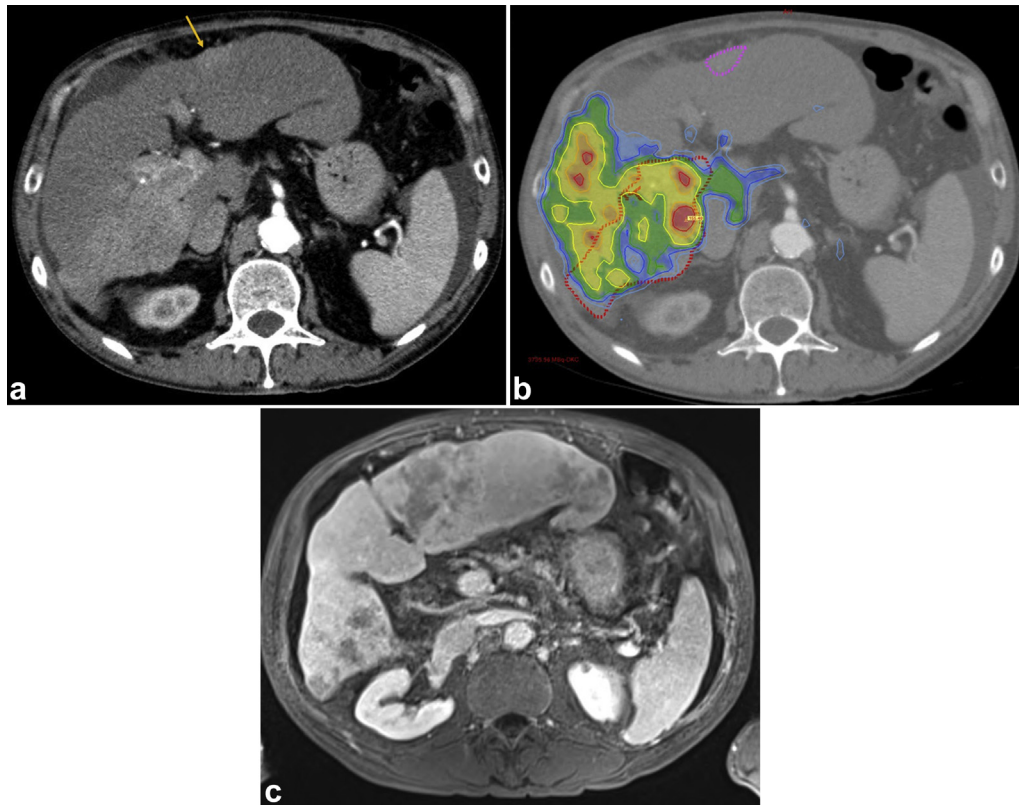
Example of incomplete targeting (limited contralateral disease). (a) Baseline CT scan with infiltrative HCC in the right lobe with right portal vein invasion and a small HCC nodule in the left lobe (arrow). (b) ^{90}Y PET/CT performed after RE in the right liver lobe shows good targeting of both infiltrative HCC and right portal vein invasion. (c) Magnetic resonance imaging performed 6 months after RE shows partial response in the right lobe but great progression of HCC in the left lobe.
